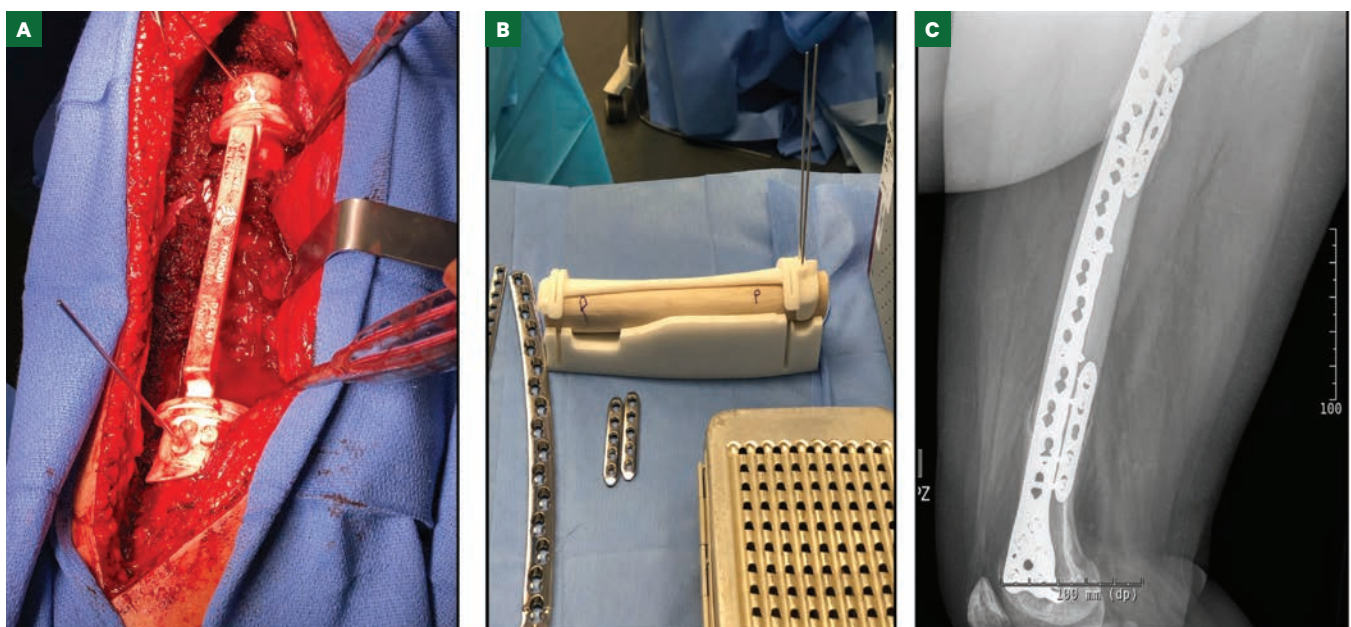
Images from Resection of a Femoral Chondrosarcoma in a 38-Year-Old Female, Using 3-Dimensional (3D)-Printed Cutting Guide. A, Intraoperative photograph of the 3D-printed cutting guide used during resection. B, Intraoperative photograph of the femoral allograft in the 3D-printed cutting guide used during resection and intercalary allograft reconstruction. C, Three-month postoperative radiograph of the femur showing new bone formation at both junctional sites.
